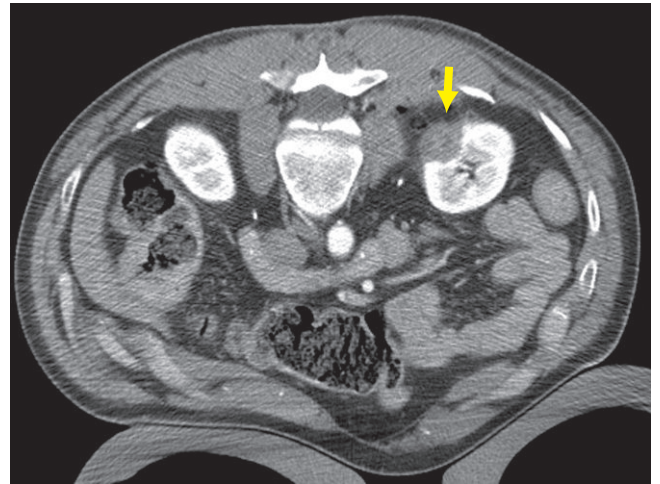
A contrast-enhanced CT scan performed immediately after radiofrequency ablation of the mass demonstrates the mass has been completely ablated and there is no evidence of any enhancement (arrow).
